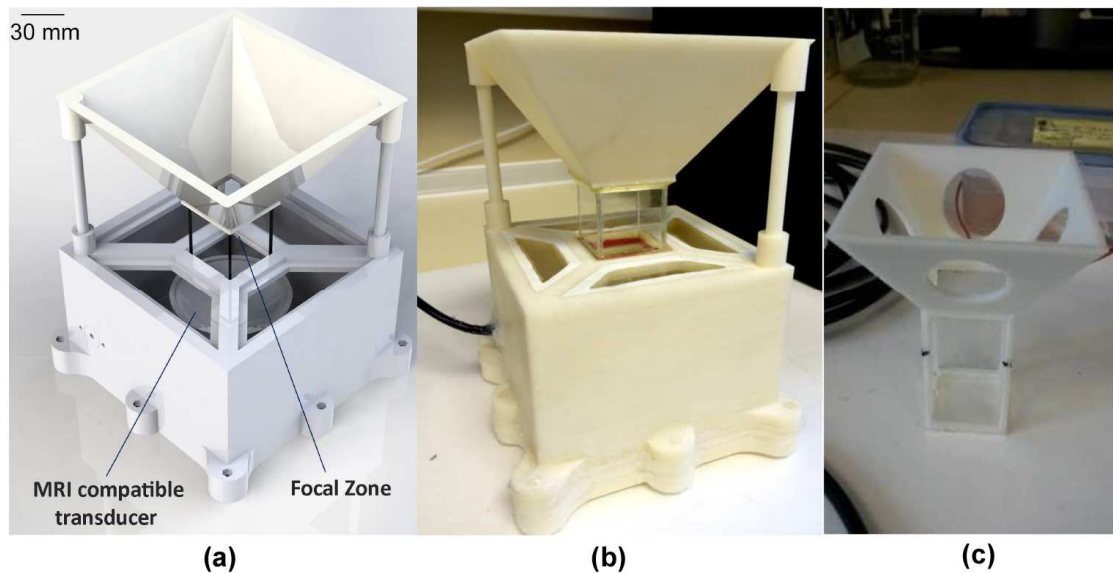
MRI compatible HIFU chamber (a) designed and (b) developed. (c) Tissue holder
